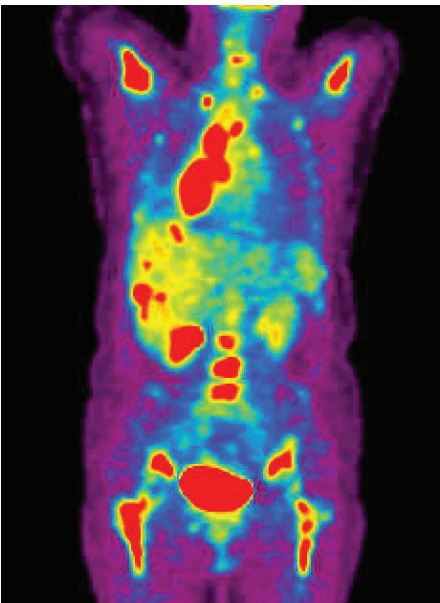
PET SCAN. Coronal PET image confirms active tumor in the right lower lobe and demonstrates extensive bilateral mediastinal nodal uptake compatible with tumor. PET also shows multiple hypermetabolic foci in the liver highly suspicious for metastases, despite the normal appearing liver on CT.
